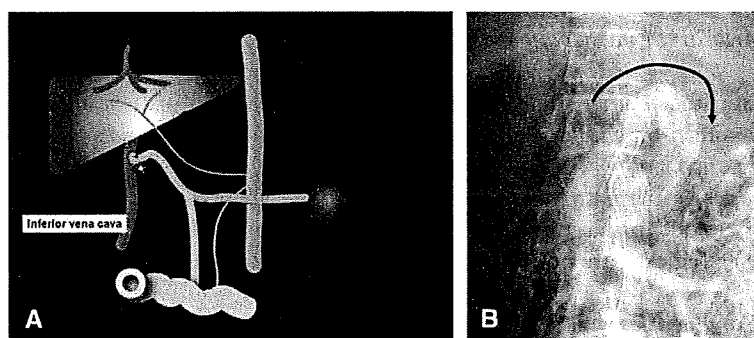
Extrahepatic portal vein obstruction (EHO)/portal vein thrombosis A Circulatory disturbance in EHO/portal vein thrombosis. The affected site is the extrahepatic portal vein (*star*). Collateral pathways of the portal vein (cavernous transformation) develop in the hepatic hilum. B Computed tomography (CT) during arterial portography in a case of EHO shows right portal
